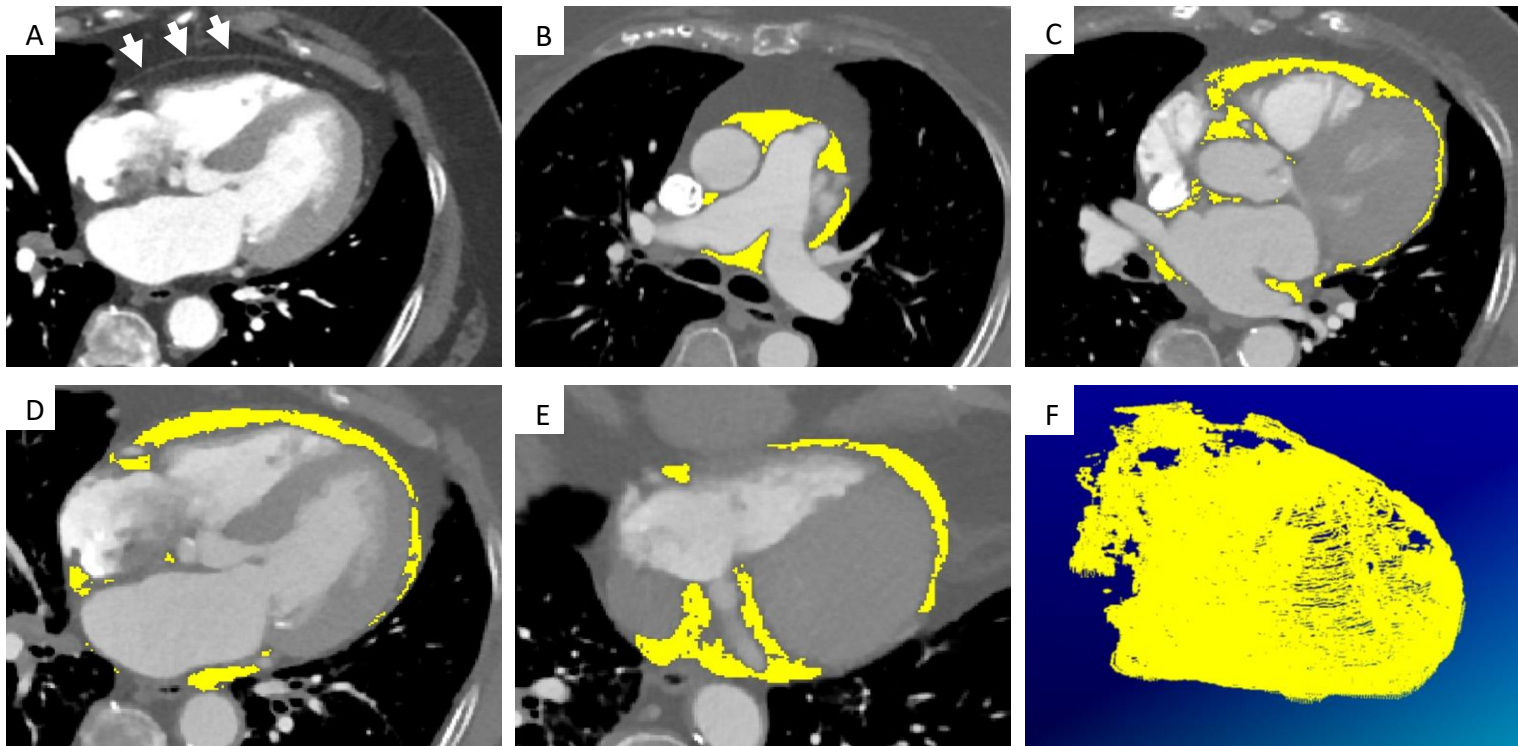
Typical cardiac CT, with contrast, demonstrating the fibrous pericardium (A, white arrows) and subsequent segmentation of epicardial adipose tissue (EAT) within the fibrous pericardium. Using a software package, EAT was segmented based on a Hounsfield unit thresholds of -190 to -30 from the bifurcation of the pulmonary artery (B) continuing to the diaphragm. Images C-E represent examples of slices taken from the mid atrial level, mid-ventricular 4-chamber and lower ventricular 4 chamber view respectively. Epicardial adipose tissue was manually redefined every 3 slices in order to correct contours and avoid inclusion of paracardial adipose tissue (outside the pericardial sac). The software calculated the EAT volume (cm^3) by summing the EAT area in each slice and taking into account slice thickness and intersection gap. Image F represents a 3D reconstruction of the EAT in this patient (a female with BMI $35.4\text{kg}/\text{m}^2$ and EAT volume of 108.6 cm^3 and iEAT of $56.77\text{ cm}^3/\text{m}^2$).
